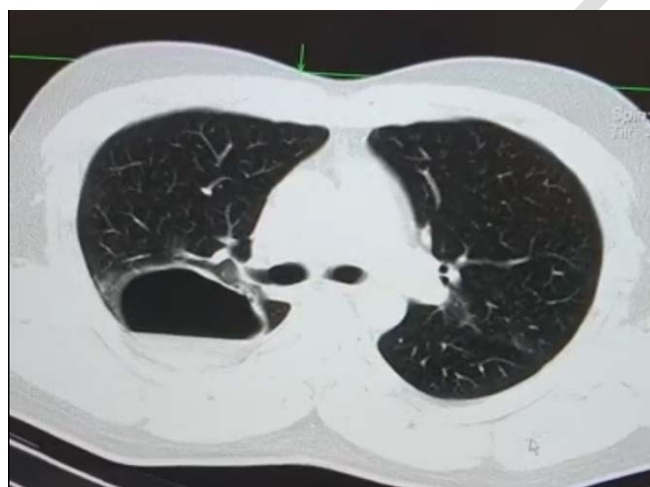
Axial Slice Computed Tomography showed spontaneous resolution of pneumothorax and increased air-fluid level inside pneumatocele
